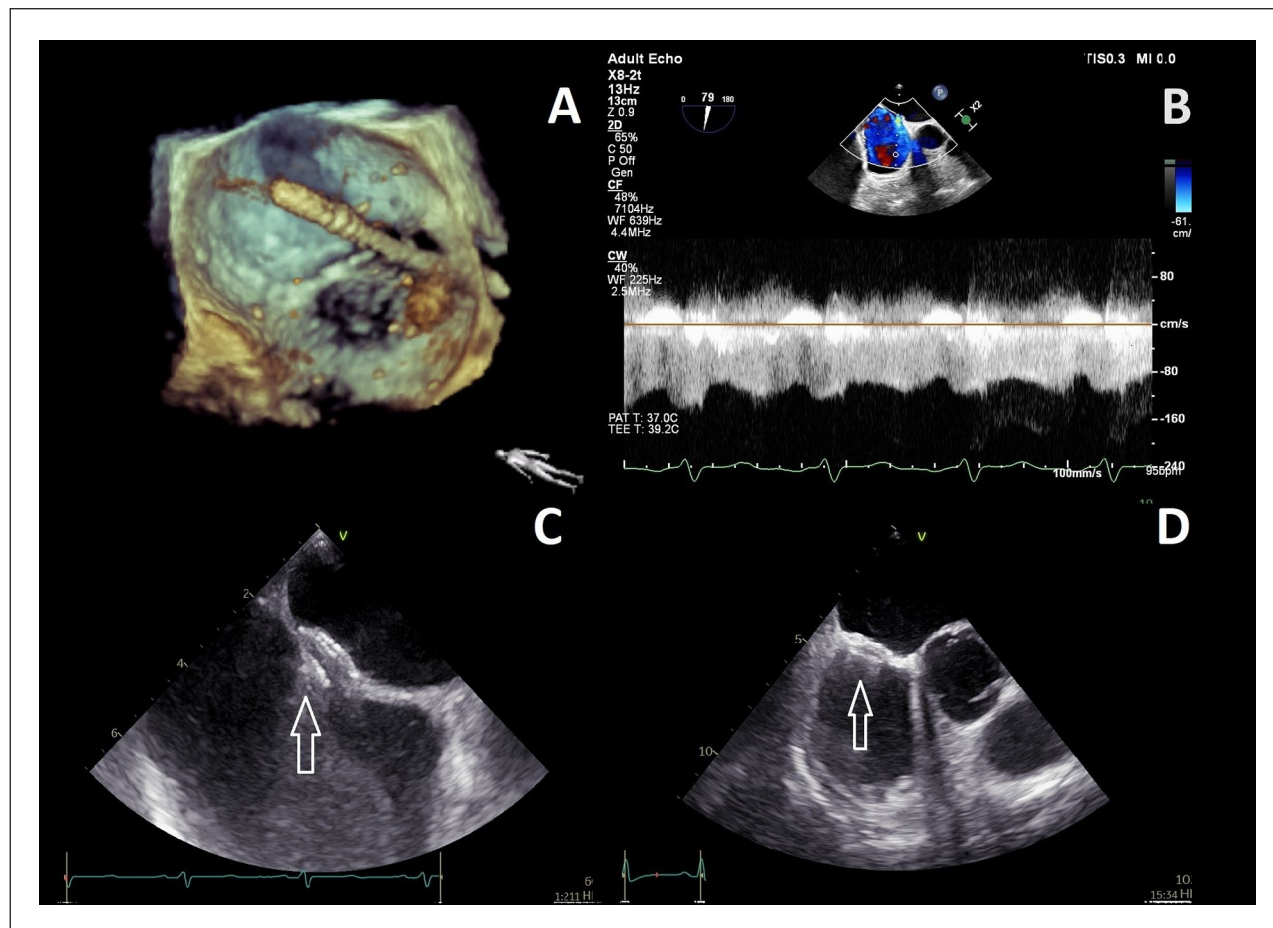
Development of iatrogenic atrial septal defect resulting from the MitraClip, along with its subsequent management involving the employment of the Amplatzer occluder for closure. (A) MitraClip system catheter passing through the atrial septum. (B) Doppler spectra of flow through an iatrogenic atrial septal defect. (C and D) Visualization of the implanted occluder on transesophageal echocardiography. Arrows indicate the occluder.
